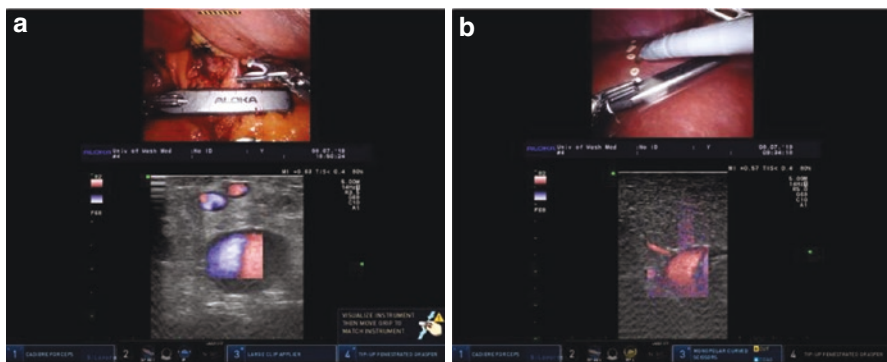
Ultrasound images visualized on TilePro display. (a) Confirmation of the hilar structures by ultrasound. (b) Ultrasound guided marking of surgical margin
